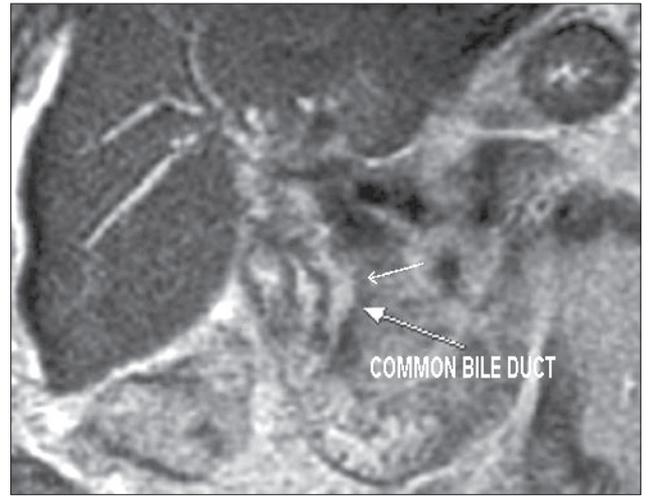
Coronal T2-weighted MR image shows focal narrowing in the right hepatic duct and dilated ducts proximal to it. Additionally, irregularities in the common bile duct contours and pseudodiverticula formation among the wall are noteworthy (*arrow*).
